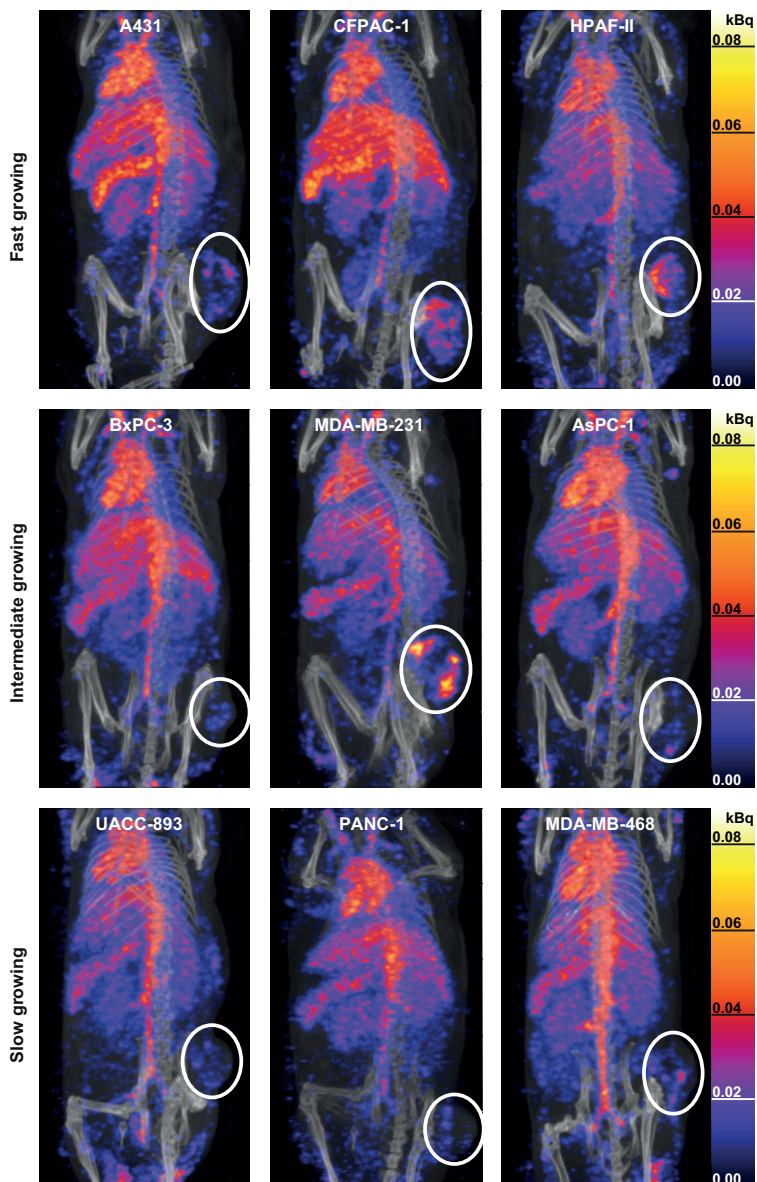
Representative SPECT/CT scans of fast, intermediate, and slow growing tumors 12 h after injection. The scans have been set to the same threshold (in kBq) to compensate for indium-111 half-life. Tumors are circled in white and show uptake of liposomes to various degrees.
